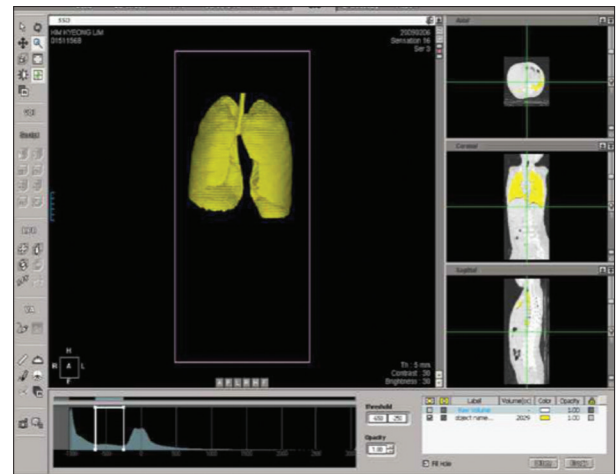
Postoperative measurement of total lung volume using 3-dimensional (3D) computed tomography (CT). It is important to note that implant *in situ* does not interfere with 3D CT based measurement
